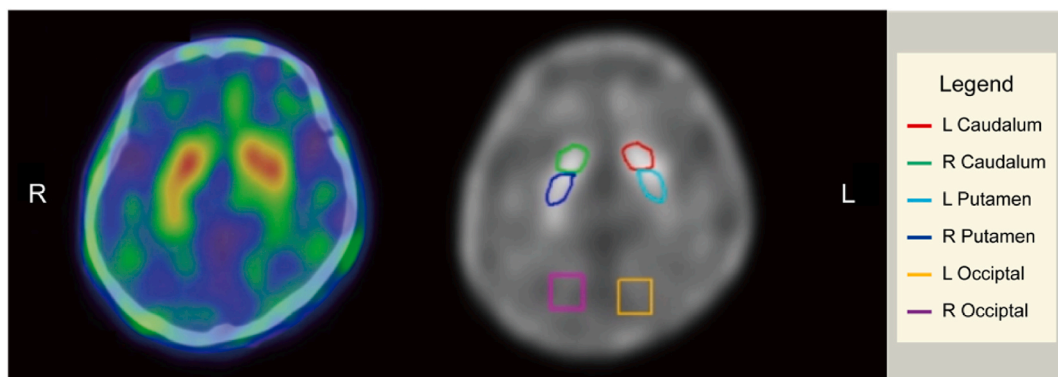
Technetium-99m-labeled tropine derivative single-photon emission computed tomography (SPECT) disclosed mild to moderate reduction of dopamine transporter-1 avidity in the bilateral putamina, especially the left posterior segment. Heterogeneous dopamine transporter-1 avidity in the bilateral caudate head. Heterogeneous dopamine transporter-1 avidity in the bilateral caudate body, with a relatively more pronounced reduction on the left side.
